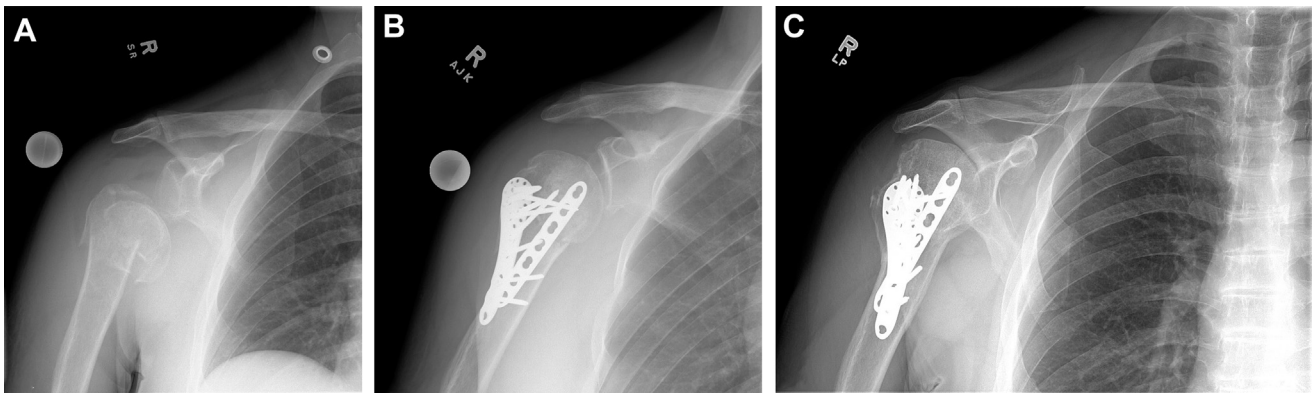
Preoperative (A), postoperative (B), and 13-month follow-up (C) anteroposterior radiographs of a displaced 3-part proximal humerus fracture.
